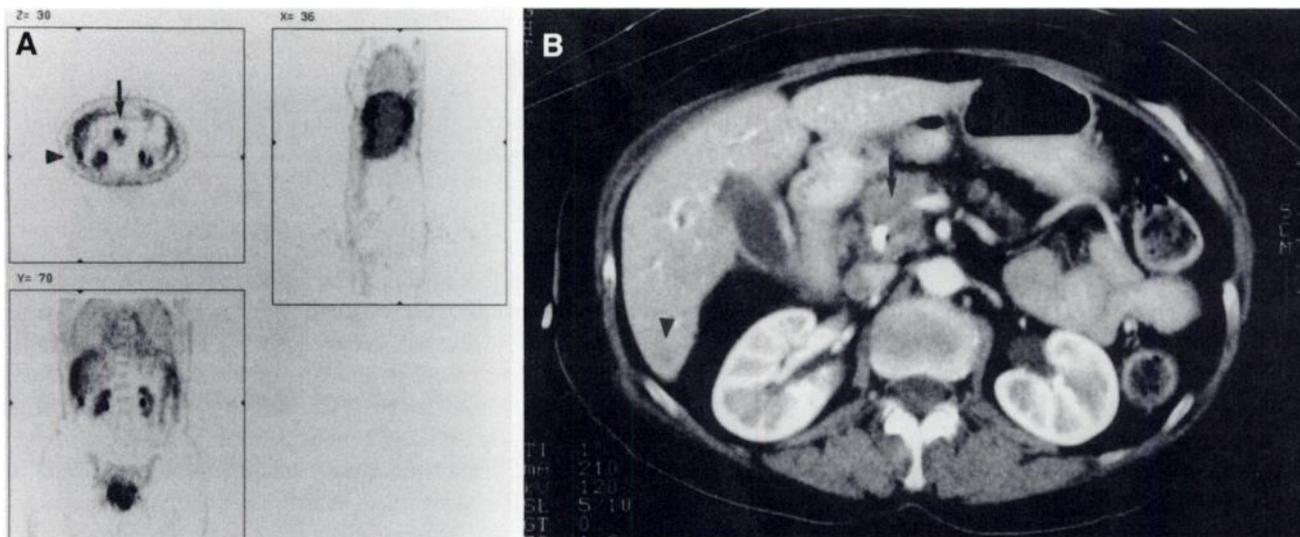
(A) PET images without attenuation correction of 59-y-old woman with biliary obstruction and lesion in head of pancreas on CT (not shown). PET images (transverse, top left; coronal, bottom; sagittal, right) show uptake in pancreatic head as expected (arrow) but also show focus of increased FDG uptake in liver consistent with small metastasis (arrowhead). (B) Thin-cut repeat CT scan shows equivocal lesion in that location (arrowhead). Lesion was explored, and small metastasis was proven by pathology.
